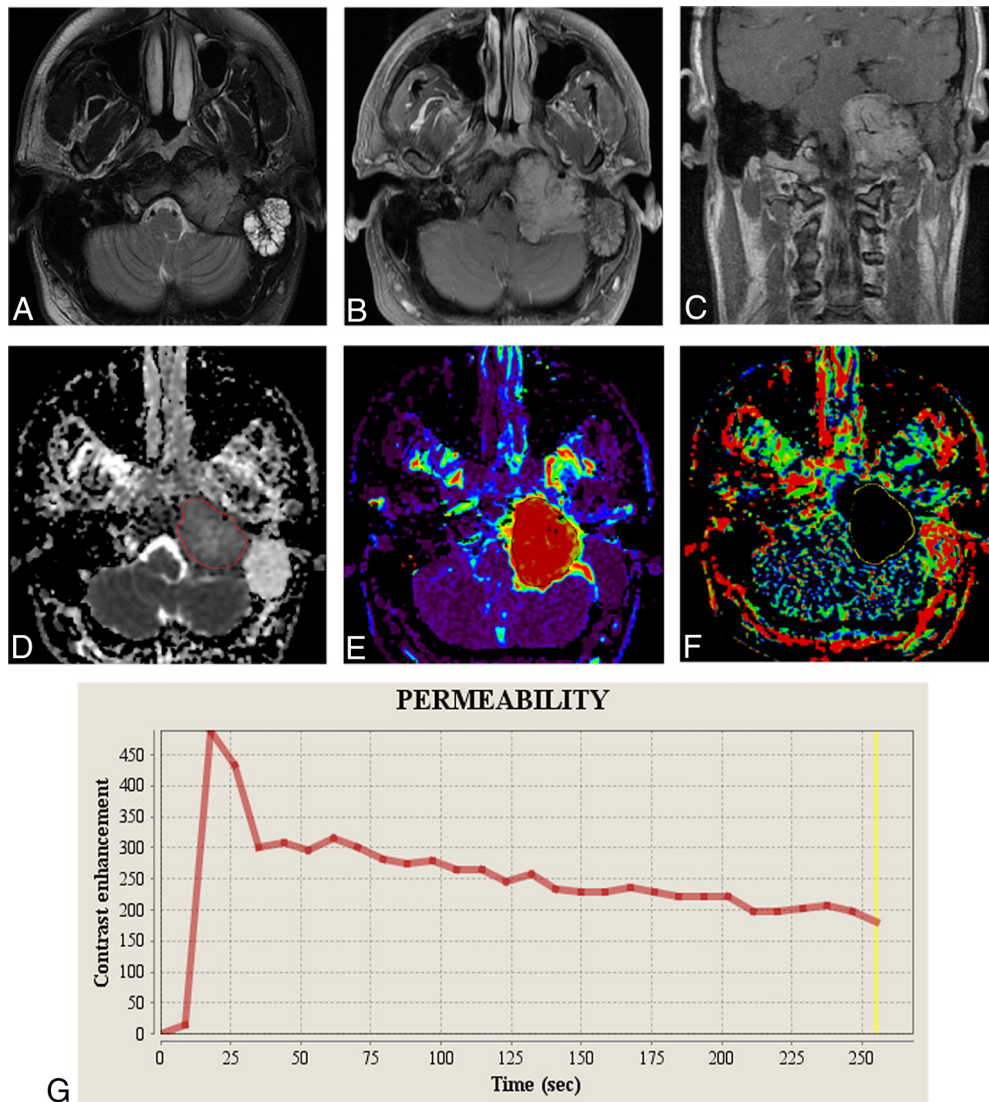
A 26-year-old man positive for the *SDHB* mutation with a paraganglioma in the left jugular foramen. A, T2-weighted image shows a heterogeneous irregular mass in the left jugular foramen. B and C, Contrast-enhanced T1-weighted images show a heterogeneous, enhancing mass with a vascular flow void. D, Mean ADC and normalized mean ADC are $1.12 \times 10^{-3} \text{ mm}^2/\text{s}$ and 1.48. E and F, Vp and TME are demonstrated. G, The TIC demonstrates a higher peak enhancement with a shorter time-to-peak compared with Fig 1.
